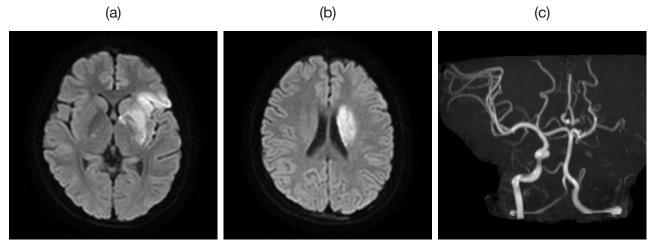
The magnetic resonance image obtained at admission shows a cerebral infarction in the left insular cortex and putamen (a, b). The magnetic resonance angiogram shows a left internal carotid artery occlusion (c).
